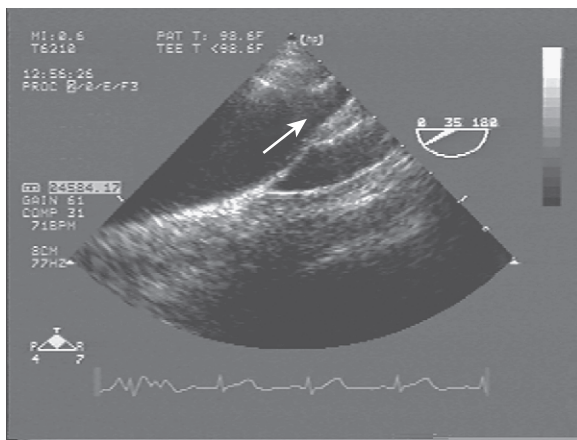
Transesophageal echocardiography visualization of the midportion to distal portion of the aortic arch. The takeoff of the left subclavian artery is visible (arrow).
